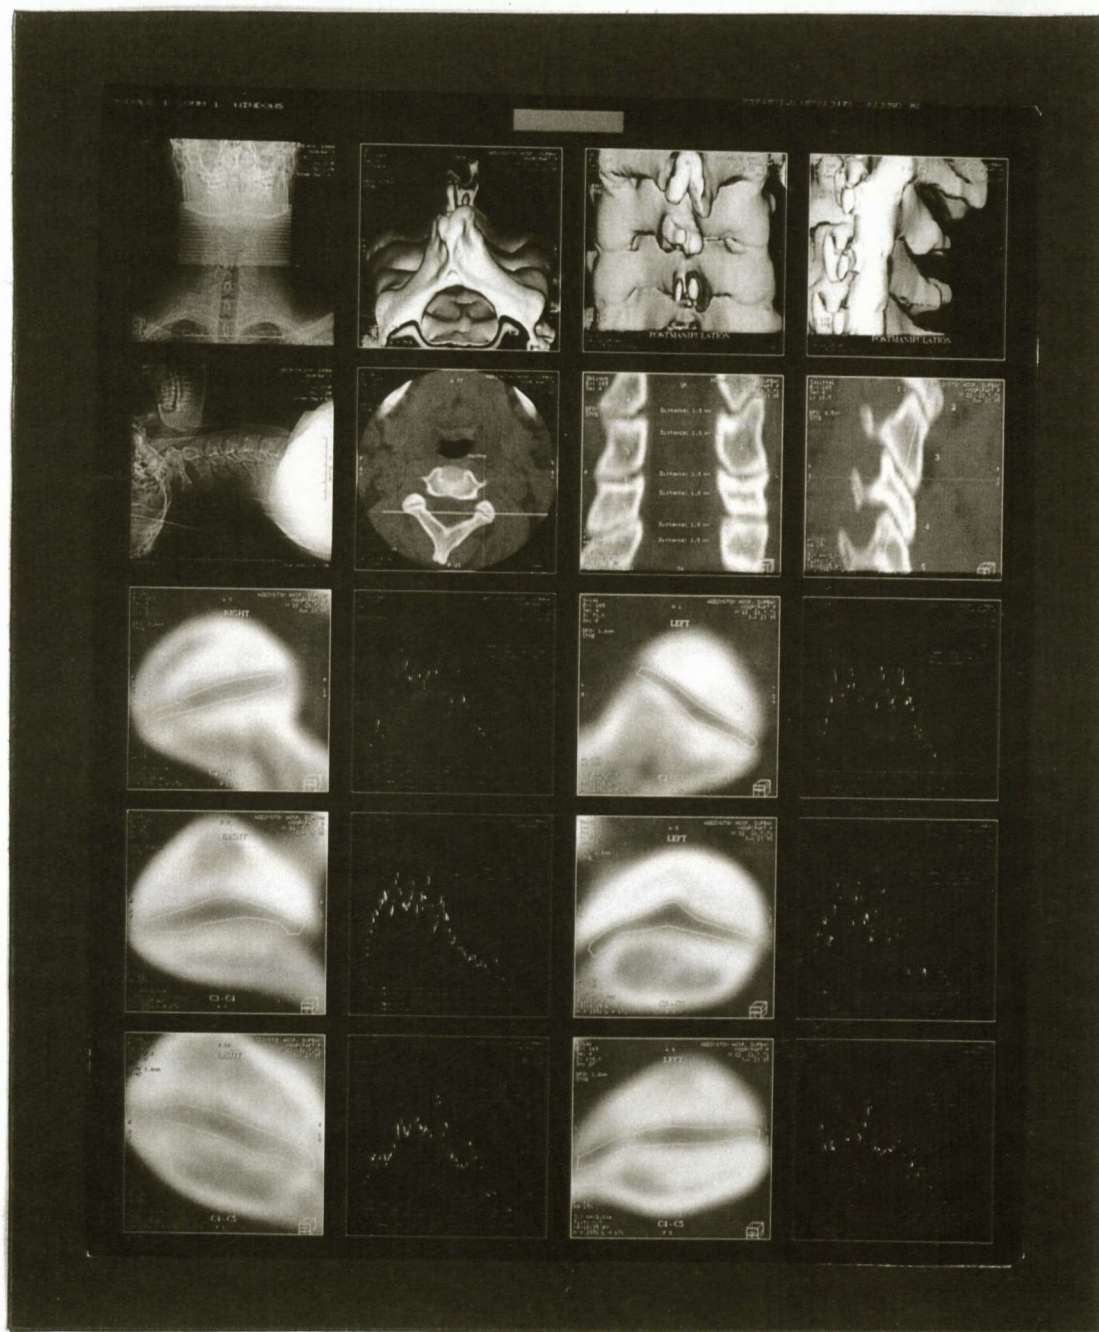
Experiment 3 : Post-manipulation + 5kg traction CT scan
